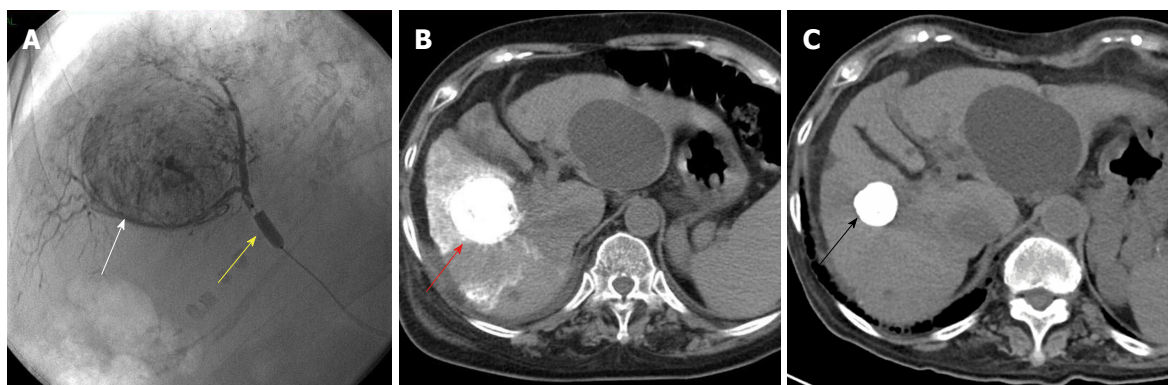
A 71-year-old female patient with hepatitis-C related hepatocellular carcinoma 45 mm in diameter underwent balloon-occluded transcatheter arterial chemoembolization. A: A 3-Fr microballoon catheter was inserted into a tumor-feeding artery. After achieving occlusion with the microballoon catheter (yellow arrowhead), emulsion of lipiodol and miriplatin was infused until the cancer nodule (white arrowhead) was sufficiently filled. Fragmented gelatin sponge slurry was then injected; B: Just after B-TACE, computed tomography (CT) showed a dense lipiodol emulsion (LE) accumulation in HCC nodules (red arrowhead); C: Four years after B-TACE, CT showed that the volume of the LE accumulation was reduced (black arrowhead) with no local recurrence. HCC: Hepatocellular carcinoma; B-TACE: Balloon-occluded transcatheter arterial chemoembolization.
